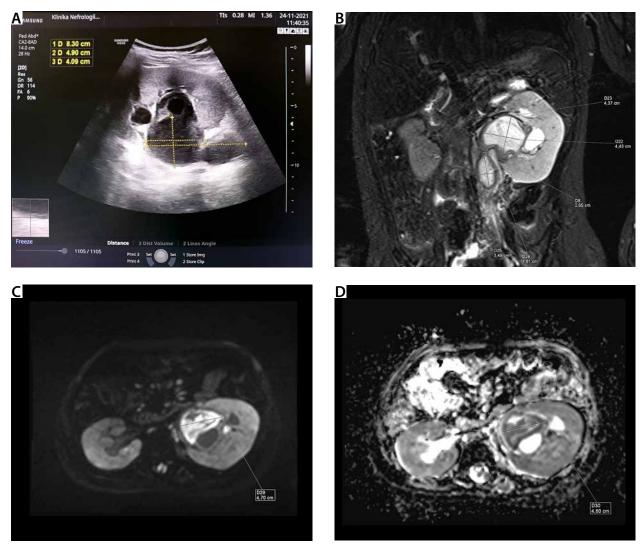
Ultrasound and magnetic resonance imaging (MRI) of the perirenal abscess. A) The ultrasound image shows a well-defined, hourglass-shaped, hypoechoic focus with a limited area of concentrated fluid. B) MRI examination with T2-weighted images in the coronal view allowed more accurate visualisation of the hourglass-shaped focus, which was localised in the hilum, near the pelvis of the left kidney and close to the lower pole of the kidney, with a high signal that indicated a fluid nature. C) examination in the axial view showing a high diffusion-weighted imaging (DWI) signal. D) MRI examination in the axial view showing a low apparent diffusion coefficient (ADC) map signal. DWI and ADC maps indicate restriction of water diffusion, which implies the presence of an abscess
